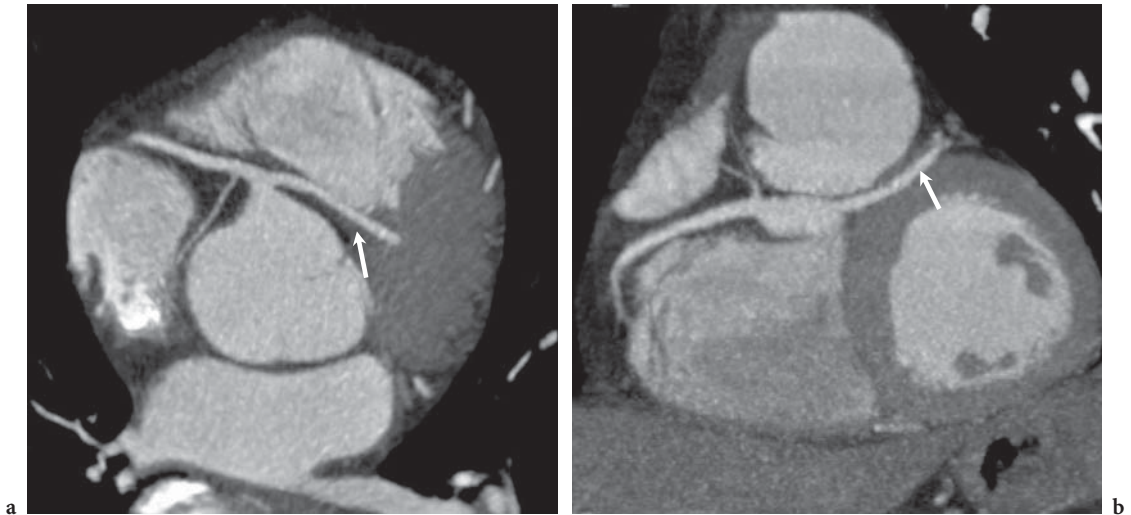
Common origin of the right and left coronary arteries displayed with axial maximum-intensity projection (MIP) (a) and double-oblique MIP (b). Scan data were acquired using 64-slice CT. The intramural course of the left coronary artery (*arrow*) between the aorta and the pulmonary outflow tract caused angina in this patient
